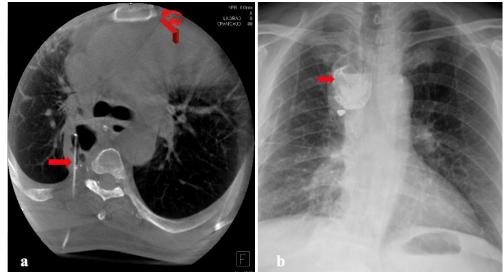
Images of the application of interventional embolization to the thoracic fistula cavity that did not resolve with medical and surgical treatment. a) The lymphatic collection was localized in cone-beam CT (red arrow). A paravertebral safe access tract was determined. After insertion of the introducer sheath, the chylous contents were aspirated and 1.5 ml of n-butyl cyanoacrylate mixed with 10 ml of lipiodol from the introducer was injected into the cavity. b) Anterior-posterior X-ray after the embolization. The red arrows show the pouch formation at the CF leak site in the thorax.
